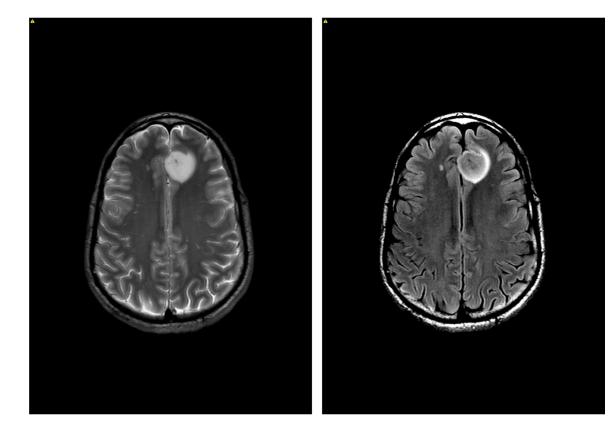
"T2-FLAIR mismatch" sign.
